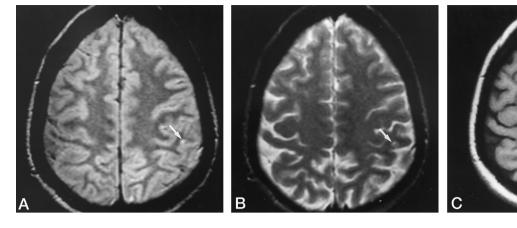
A lesion classified as an indeterminate malformation at MR imaging and as an AVM at angiography. Axial proton density-weighted (2000/
